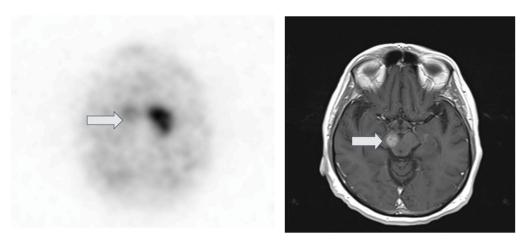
65-year-old male with history of low-grade glioma in right midbrain evaluation for right arm rigidity and tremor. 4a. Axial brain SPECT showing decreased uptake in the right caudate and absent uptake in the right putamen due to right midbrain glioma (arrow). Normal comma shaped activity in the left caudate and putamen. 4b. MRI Brain T1 with contrast showing enhancing lesion in the right midbrain consistent with history of low-grade glioma.
